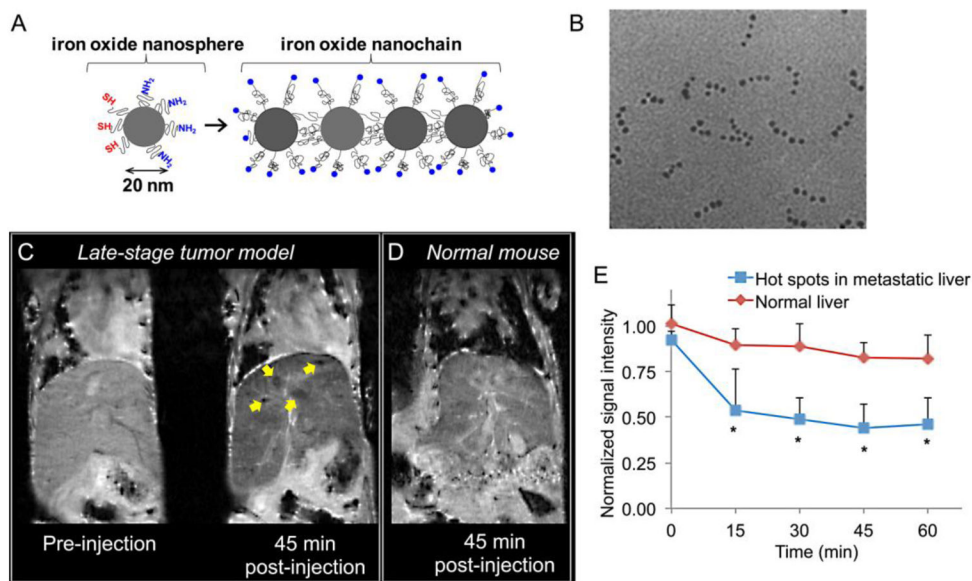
Detection of breast cancer metastasis in liver using MRI and a targeted iron oxide nanochain
